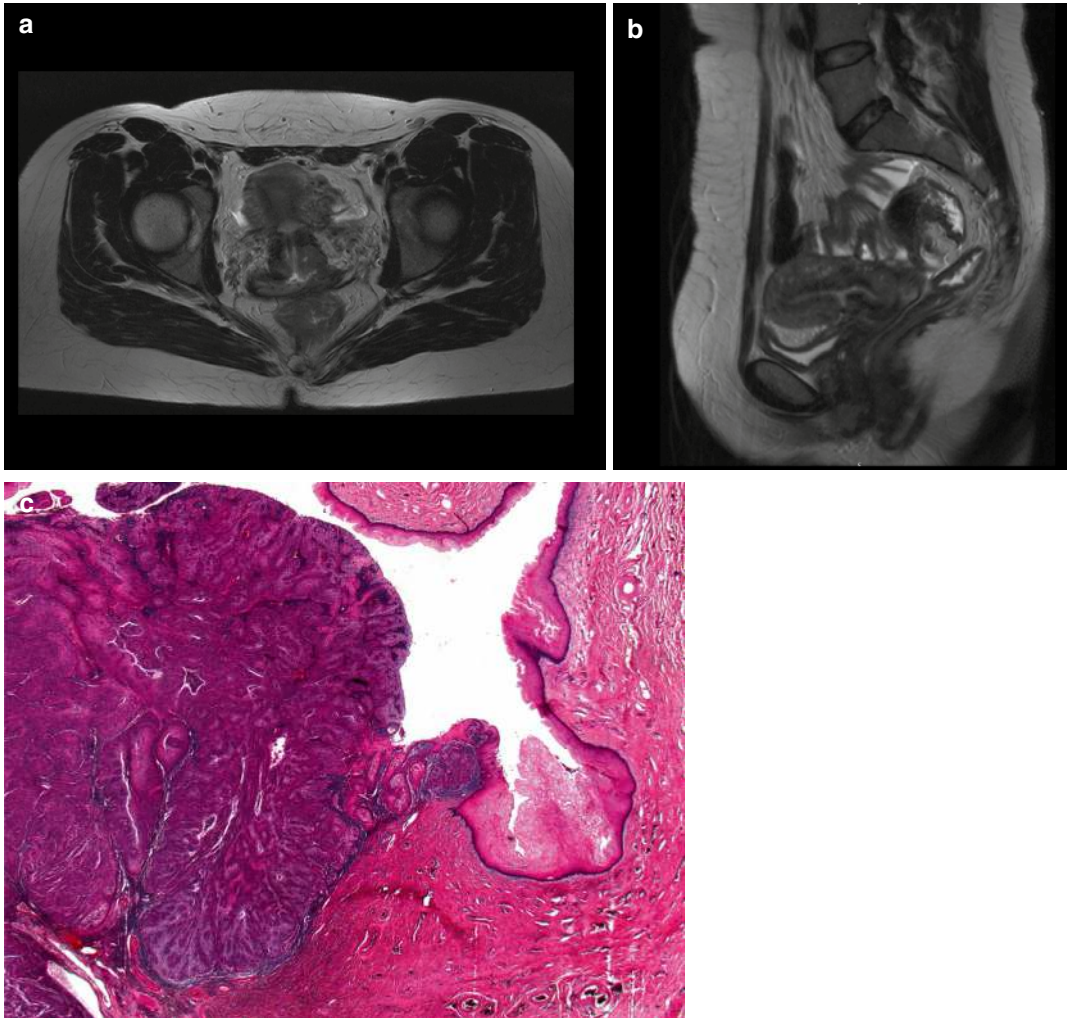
oT2 cervix carcinoma with vaginal involvement. T2-weighted transverse (a) and sagittal (b) MRI scans show neoplastic tissue in the cervical stroma and adjacent
